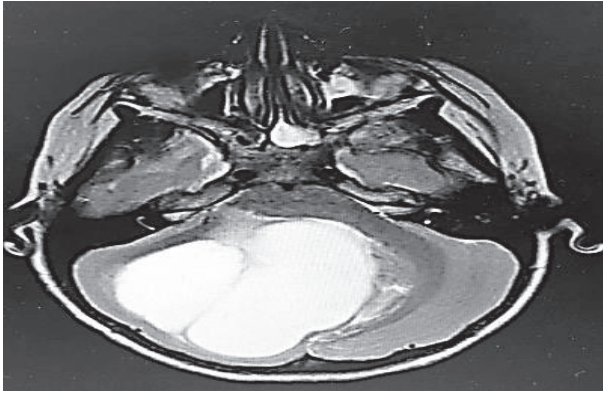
Axial MRI T2-Weighted Image Showing Cerebellar Hyperintense Lesion
